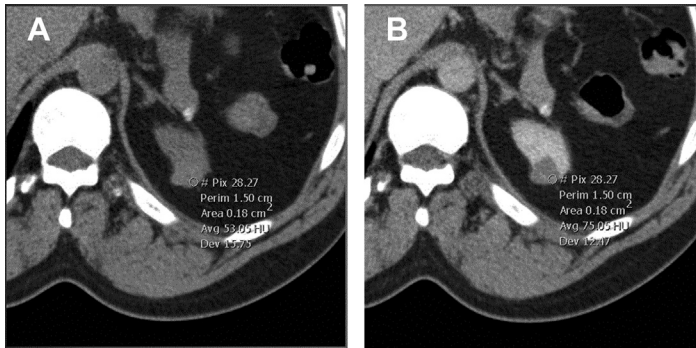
Use of small ROIs to detect enhancement. (A) Hyperdense pRCC on unenhanced axial CT image with a small ROI demonstrates an attenuation of 53 HU. (B) Nephrographic phase CT image ROI measures an attenuation of 75 HU, confirming enhancement (>20 HU difference). ROIs encompassing two-thirds of the mass measured attenuation values of 55 HU and 64 HU and were, thus, unable to detect enhancement.
